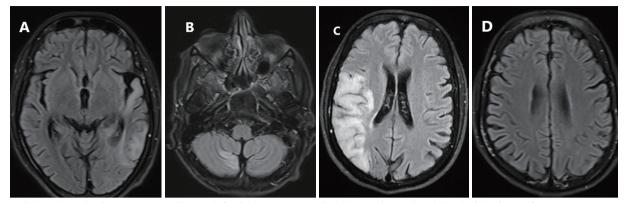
Axial FLAIR brain MRI revealing a left side temporoparietal hyperintensity (A), Axial view of DWI sequence showing right cerebellar restricted diffusion (B), Axial FLAIR imaging demonstrates increased signal on the left temporoparietal region (C), All changes in brain MRI disappear on follow-up imaging of patient 2 (D).
